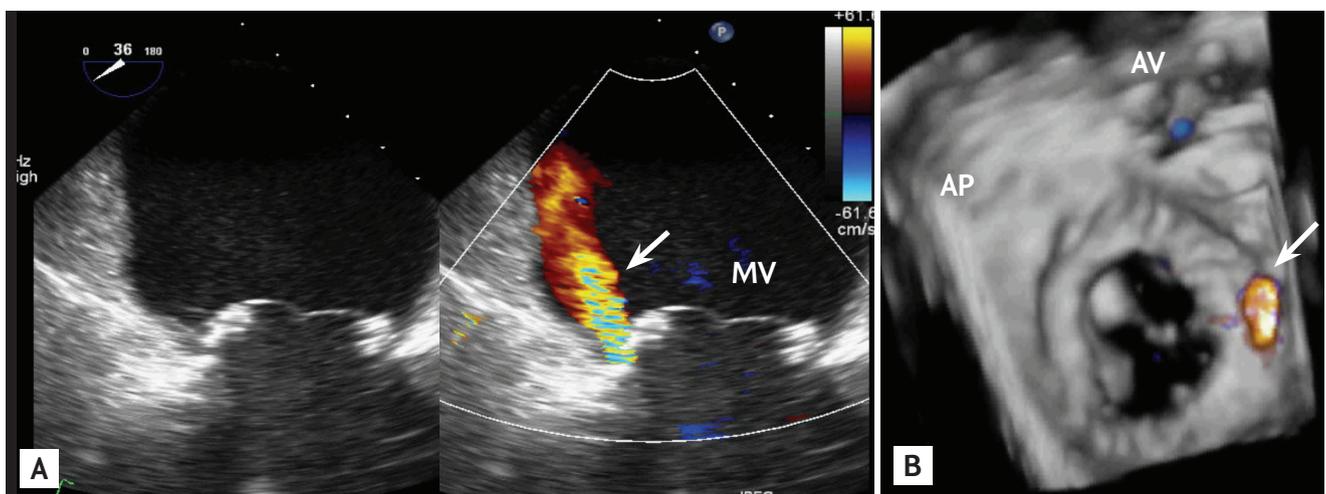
A residual mitral regurgitation immediately after surgical mitral valve replacement (a tissue valve). (A) The upper panel shows 2-dimensional (D) transesophageal echocardiography (TEE) image. (B) Color Doppler 3D TEE image could demonstrate the exact location of the residual mitral regurgitation (MR) (arrow) which could assist in second pump correction of the MR. AP, appendage; AV, aortic valve; MV, mitral valve.
